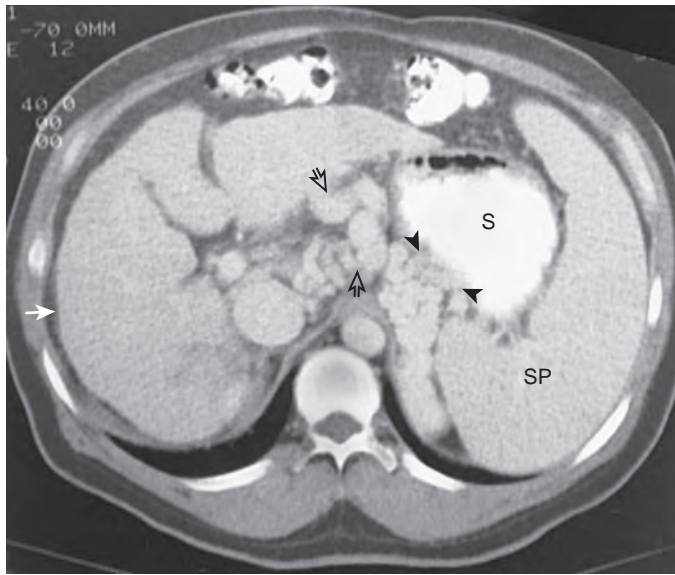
Gastric varices on CT. Enhancing collaterals are seen in the gastric wall (arrowheads), gastrohepatic ligament (open arrows), and left retroperitoneal space. This patient also has cirrhosis with splenomegaly and minimal ascites (solid arrow) caused by portal hypertension. S, stomach; SP, spleen. (Courtesy Richard M. Gore, MD, Evanston, IL.)
